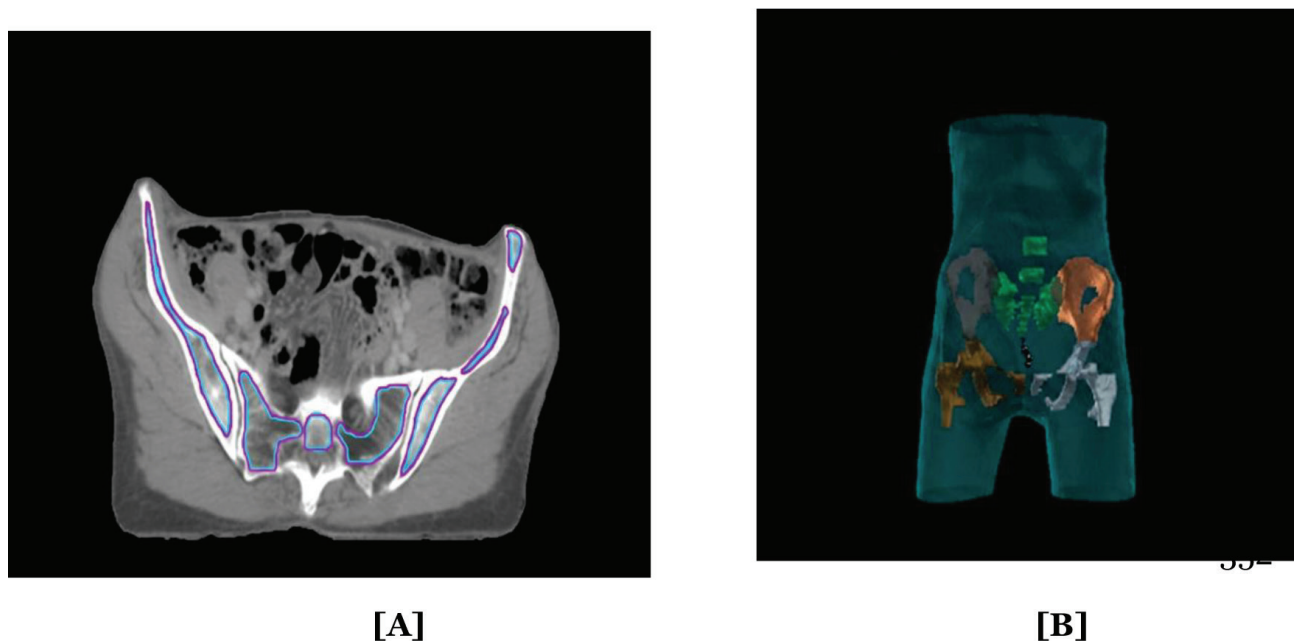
Representative images demonstrating PBM contouring. (a): CT slice showing PBM delineation. (b): Three-dimensional volumetric rendering.
